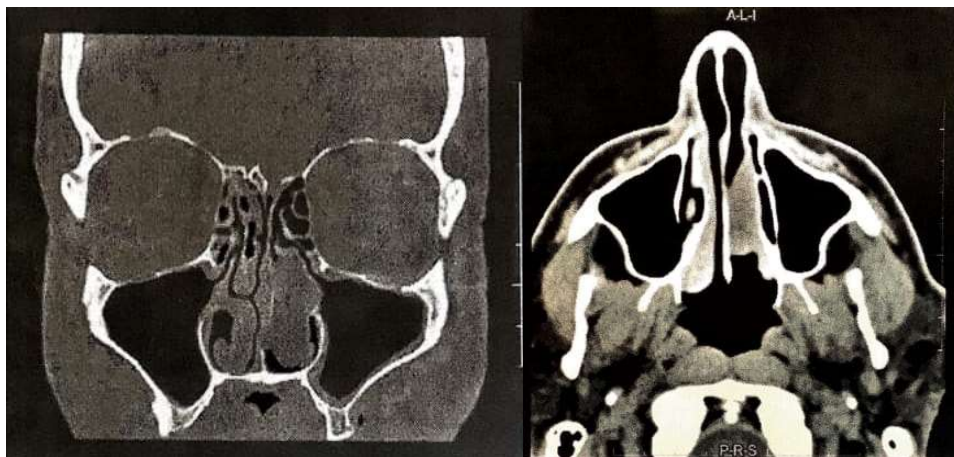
Paranasal sinuses CT-scan, showing a voluminous polyp in the left nasal fossa.
